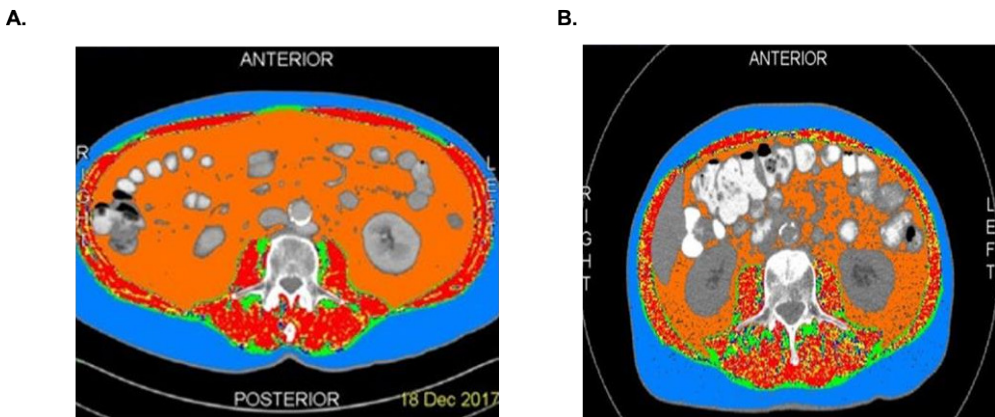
Tomovision analysis of the abdominal computed tomography scans of two individuals in our cohort A. A male patient with baseline LSMI = 55.02 cm²/m² without sarcopenia B. A male patient with baseline LSMI=39.45 cm²/m² consistent with sarcopenia.
